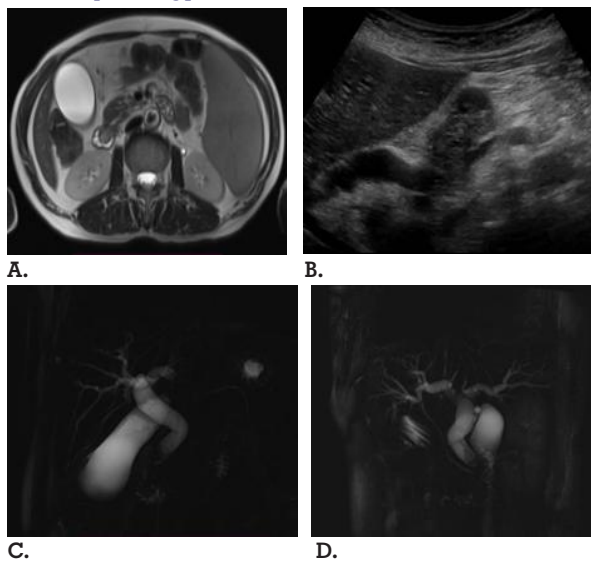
Ultrasound image shows an ill-defined hypoechoic mass in the periampullary region causing upstream dilatation of CBD.
